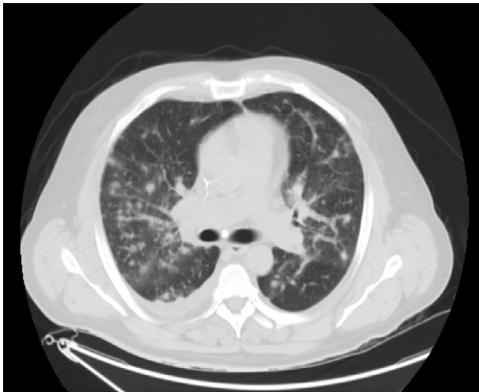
Computed tomography scan of the chest with bilateral multiple nodules.
